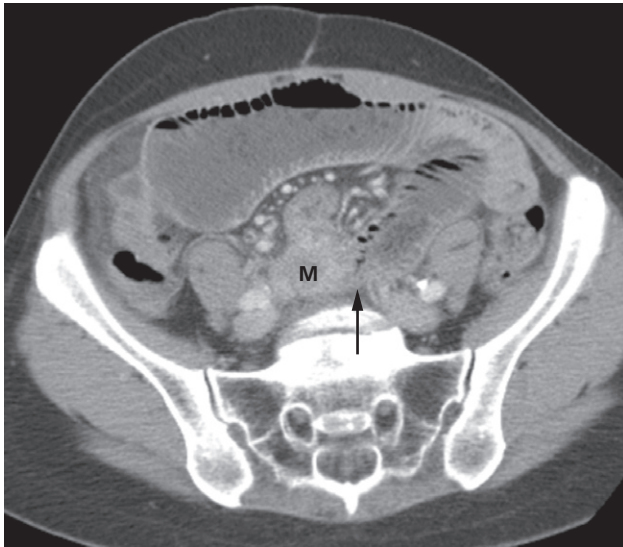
CT of small bowel obstruction in a patient with recurrent ovarian cancer. There is an abrupt change in calibre of the dilated small bowel lumen (arrow) where a mass (M) is infiltrating the bowel wall.
